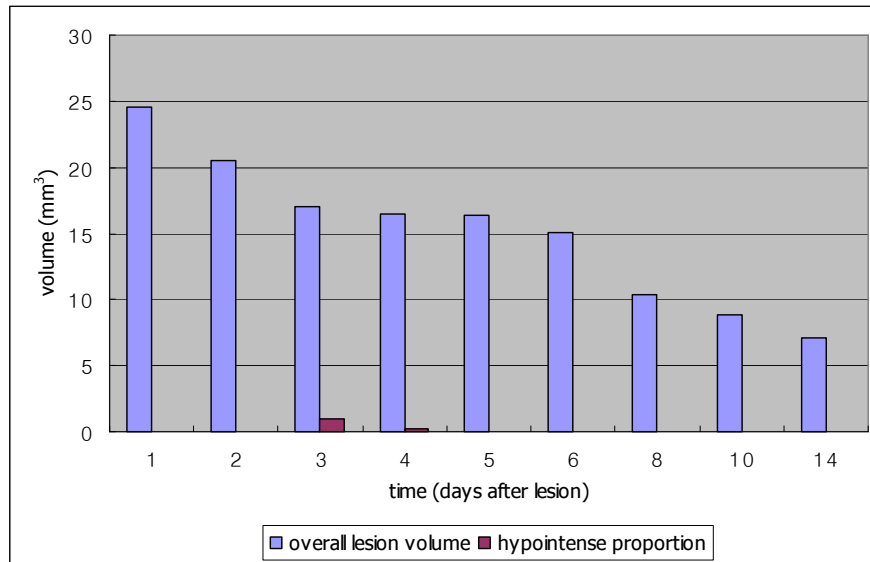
Overall lesion volume and the volume of hypointense area on T2*-weighted MR images at various stages of reperfusion. Proportion of the hypointense area in relation to total infarct volume did not significantly differ between days 3 and 4 after reperfusion.
